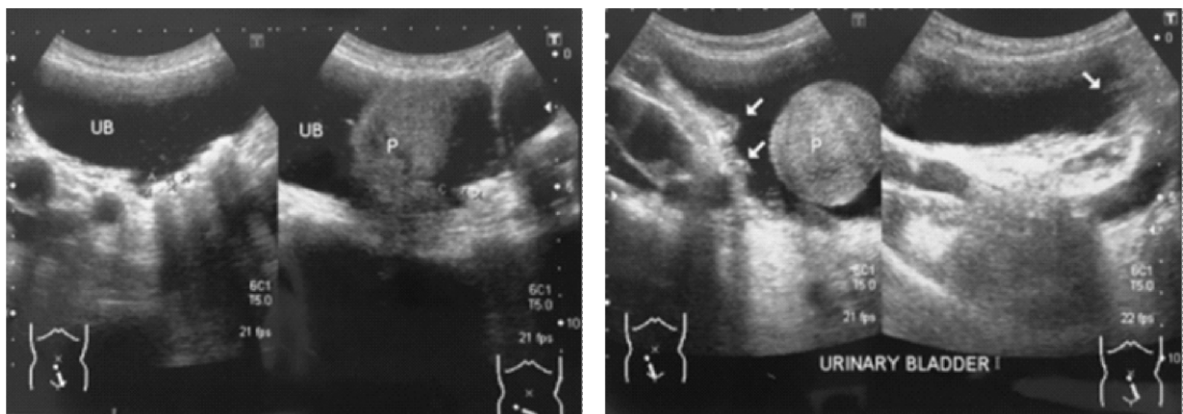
Transabdominal Ultra Sonography (USG) showed grossly enlarged prostate measuring 86 x 102 x 76 mm in size and 348 cc in volume with markedly enlarged median lobe protruding in to the bladder.
